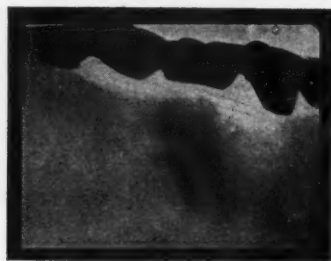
This case from the practice of Dr. Bartlett and Dr. Loeb we were unable to diagnose. We reported that a shadow consistent in size and shape with that which a tooth might make was observed under the bridge. It evidenced no root canals, however, and had no space for the peridental membrane. We asked to be advised if the pathology was ever ascertained. A few days later Dr. Loeb stated to the writer that the case had been operated and the shadow in the roentgenogram was produced by a calcium formation in the socket of the first molar. Since the time this film was made two other identical cases have been examined.
